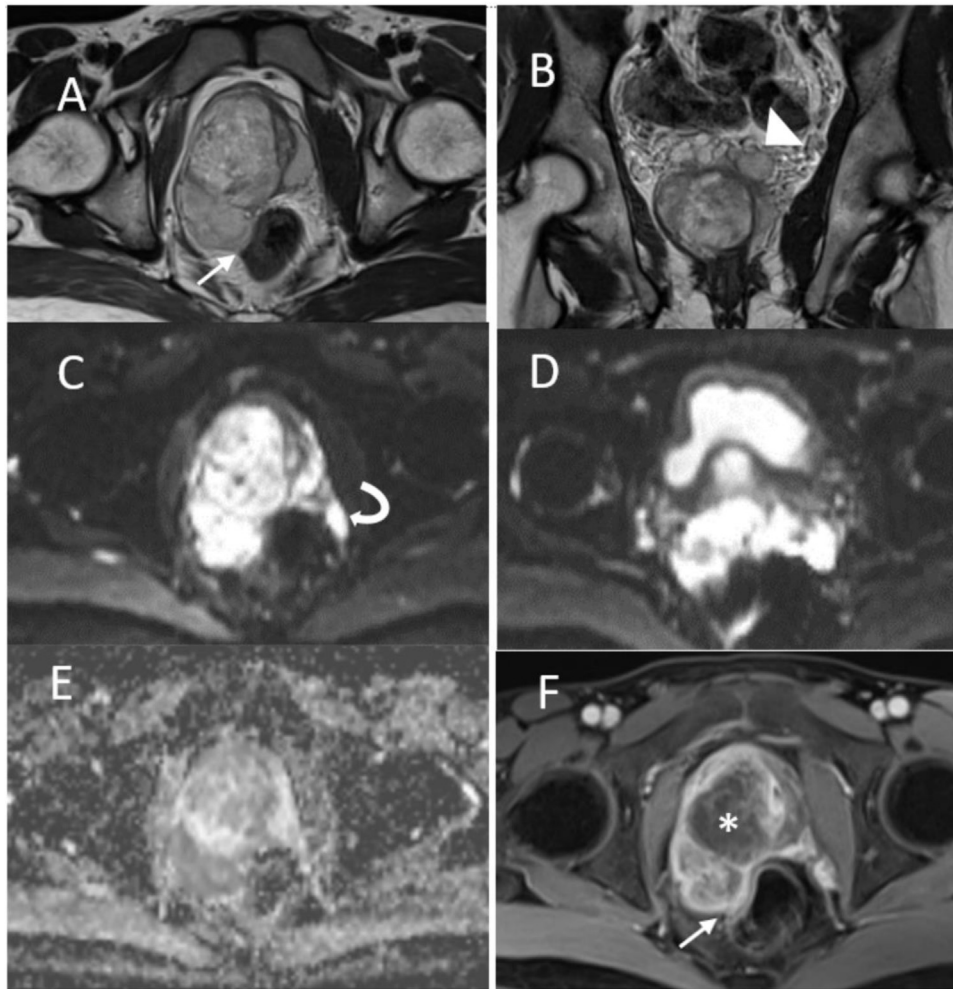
Contrast-enhanced pelvis MRI: (A) Axial T2WI, (B) Coronal T2WI, (C and D) DWI, (E) ADC, (F) T1WI postcontrast. The mass is on the right lobe of the prostate, hyper-signal on T2WI (A, B), loss of boundaries between the peripheral zone and transitional zone, uncontinuous capsule of the prostate gland, invading and pushing the rectum to the left (A, F - straight arrow). The neoplasm is hyper-signal intensity on DWI (C, D), hypo-signal on ADC (E), peripheral enhancement postcontrast sequence(F), with a nonenhanced center (asterisk). The mass invades the seminal vesicle (B- triangle) and several pelvic lymph nodes (C - curved arrow).
